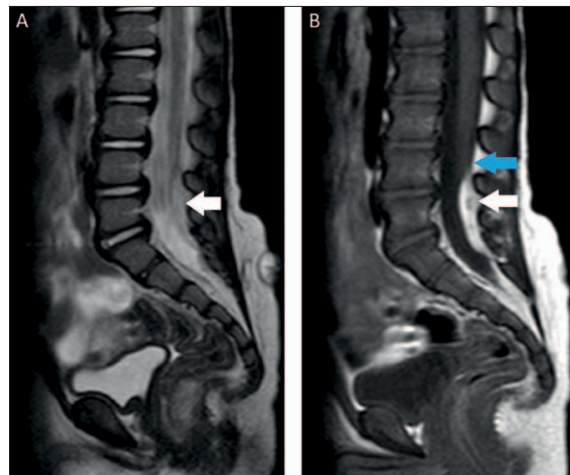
Sagittal section MRI in T2 sequence in A and T1 sequence in B, both without contrast, demonstrating medullary cord extending up to a L4 vertebral body (blue arrow) – tethered cord – with a lipoma between the dura and the bony wall in the extradural space (white arrow).
